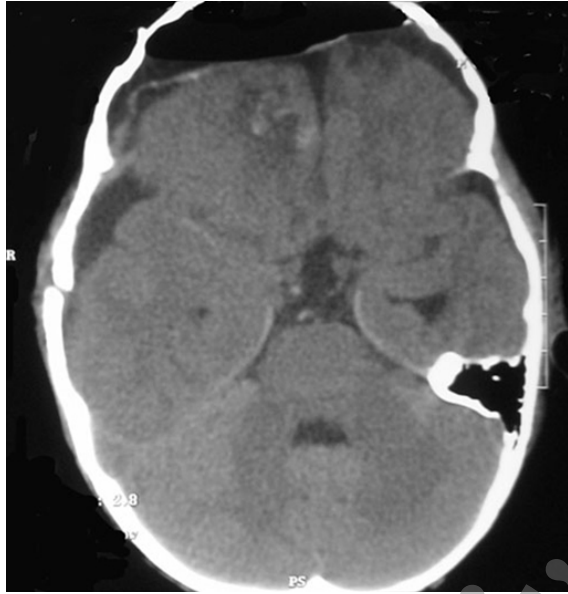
Post-operative CT scan with no tumor residue and no compression of the brain stem
